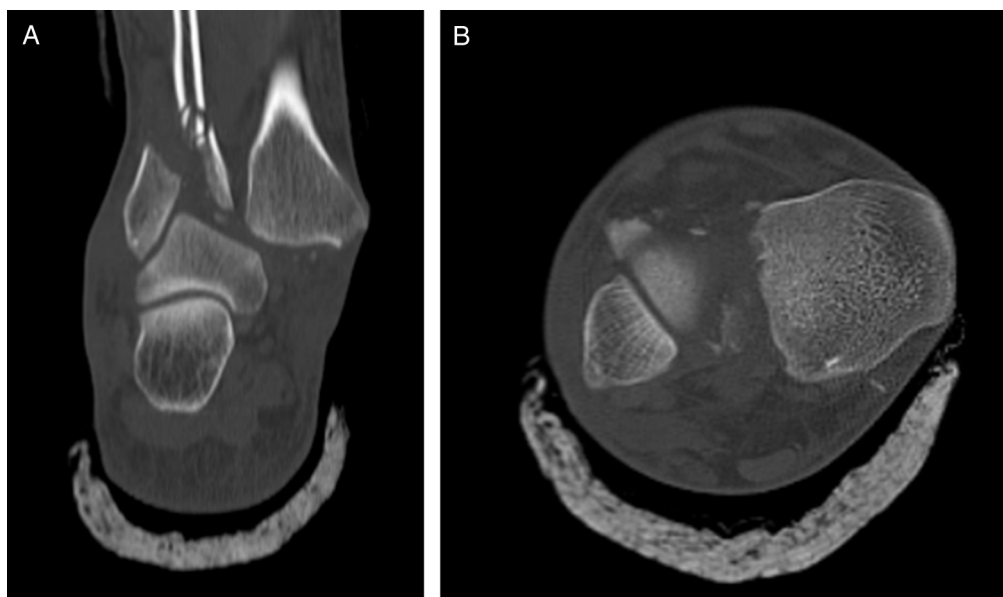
(A) Coronal and (B) axial cuts of an ankle computed tomography scan showing comminuted fracture of the fibula with multiple small fragments between the tibia and fibula.
